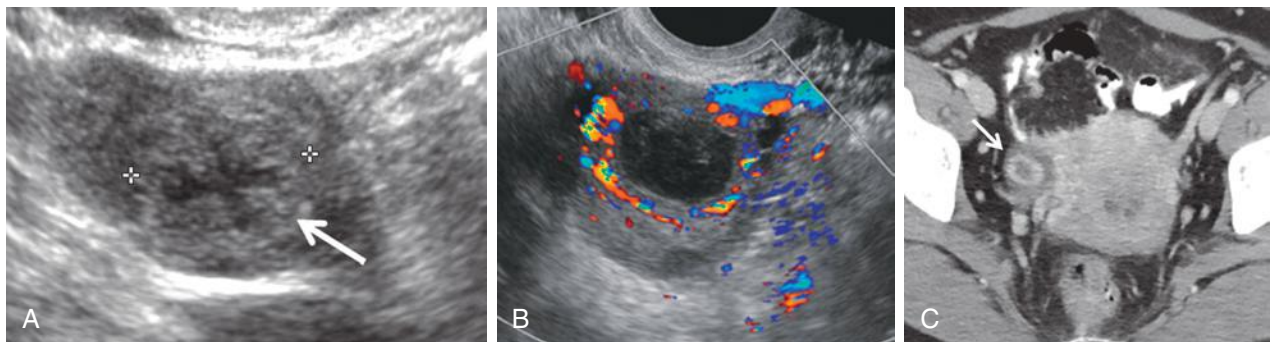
Spectrum of appearances of the corpus luteum. A, Cyst with thickened, crenulated wall (*arrow* and *calipers*). B, Typical “ring of fire” appearance on color Doppler sonogram. C, Typical appearance of corpus luteum (*arrow*) in the right ovary at contrast-enhanced computed tomography. Note enhancement of the wall of the corpus luteum.
